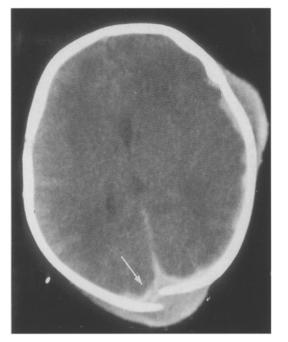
Uncontrasted CT scan: interparietal dehiscence above the superior sagittal sinus (arrow)
